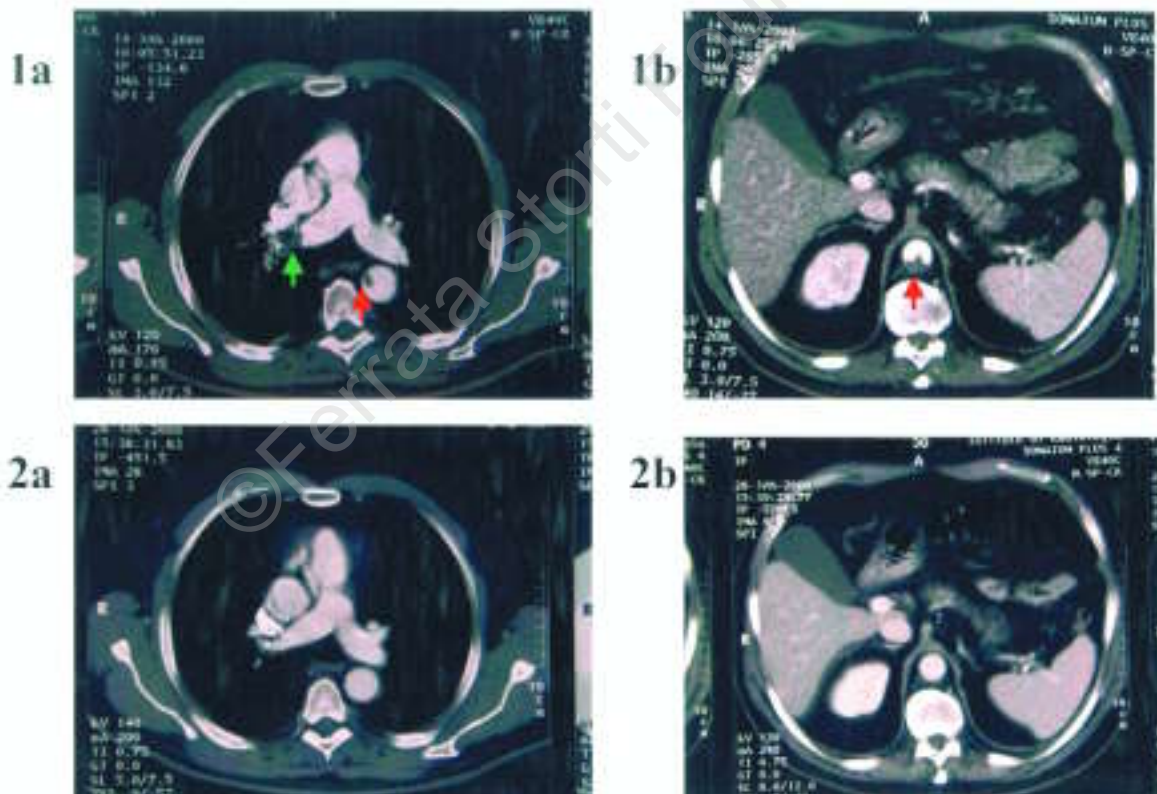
CT scan performed at admission. A. Thoracic section, showing: a floating thrombus in the thoracic aorta, (descending part, right side, red arrow); a large thrombus in the main branch of the right pulmonary artery, and a little thrombus in its distal branch (green arrows). B. abdominal section, showing a large thrombus of triangular shape in the left side of abdominal aorta (left side).
